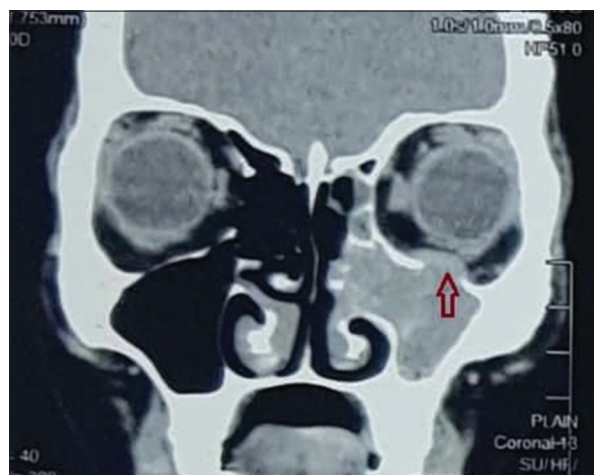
Computed tomography Paranasal sinus showing features suggestive of the left maxillary and the left ethmoidal invasive fungal sinusitis
